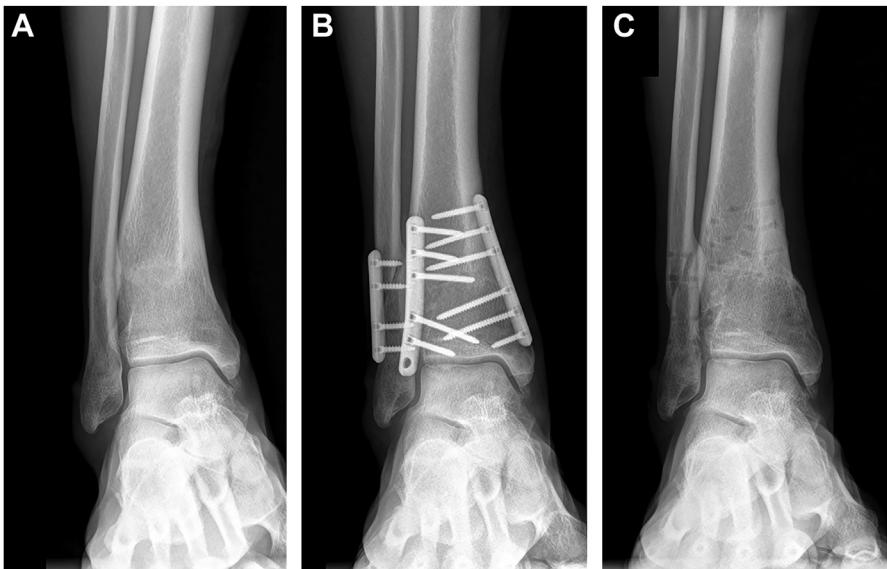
Dome osteotomy of the distal tibia. A 63-year-old male patient with stage 2 OA. AP radiographs showing (A) preoperative narrowing of the joint space only in the medial gutter; (B) 8 weeks after surgery, a congruent joint; and (C) 5 years after surgery, an excellent clinical result with the patient sensing no pain.
